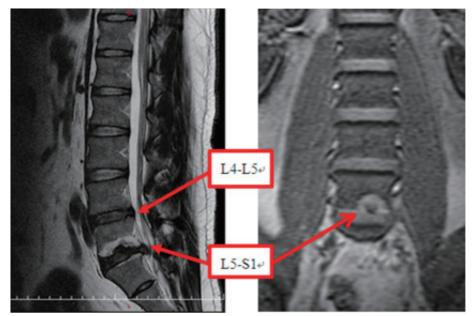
L-spine MRI sagittal (right) and coronal (left) views: red arrows indicate lumbar LIDH at the disc level between the fourth and fifth lumbar vertebral bodies (L4–L5) and between the fifth lumbar vertebral body and the first sacrum (L5–S1) with compression at the fifth lumbar and first sacral nerves.
